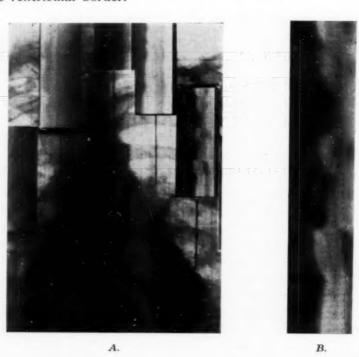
Chronic constrictive pericarditis. A, Analytic roentgenkymograms recorded on the lower and mid-portions of the left ventricle, the pulmonary artery, the aorta, and the lower and upper arches of the right border. B, Analytic roentgenkymogram of the left ventricle (natural size). Note the trapezoid pattern of the tracing recorded on the left ventricle. Read from bottom to top. Speed: 1 mm. = 3 hundredths of a second.
